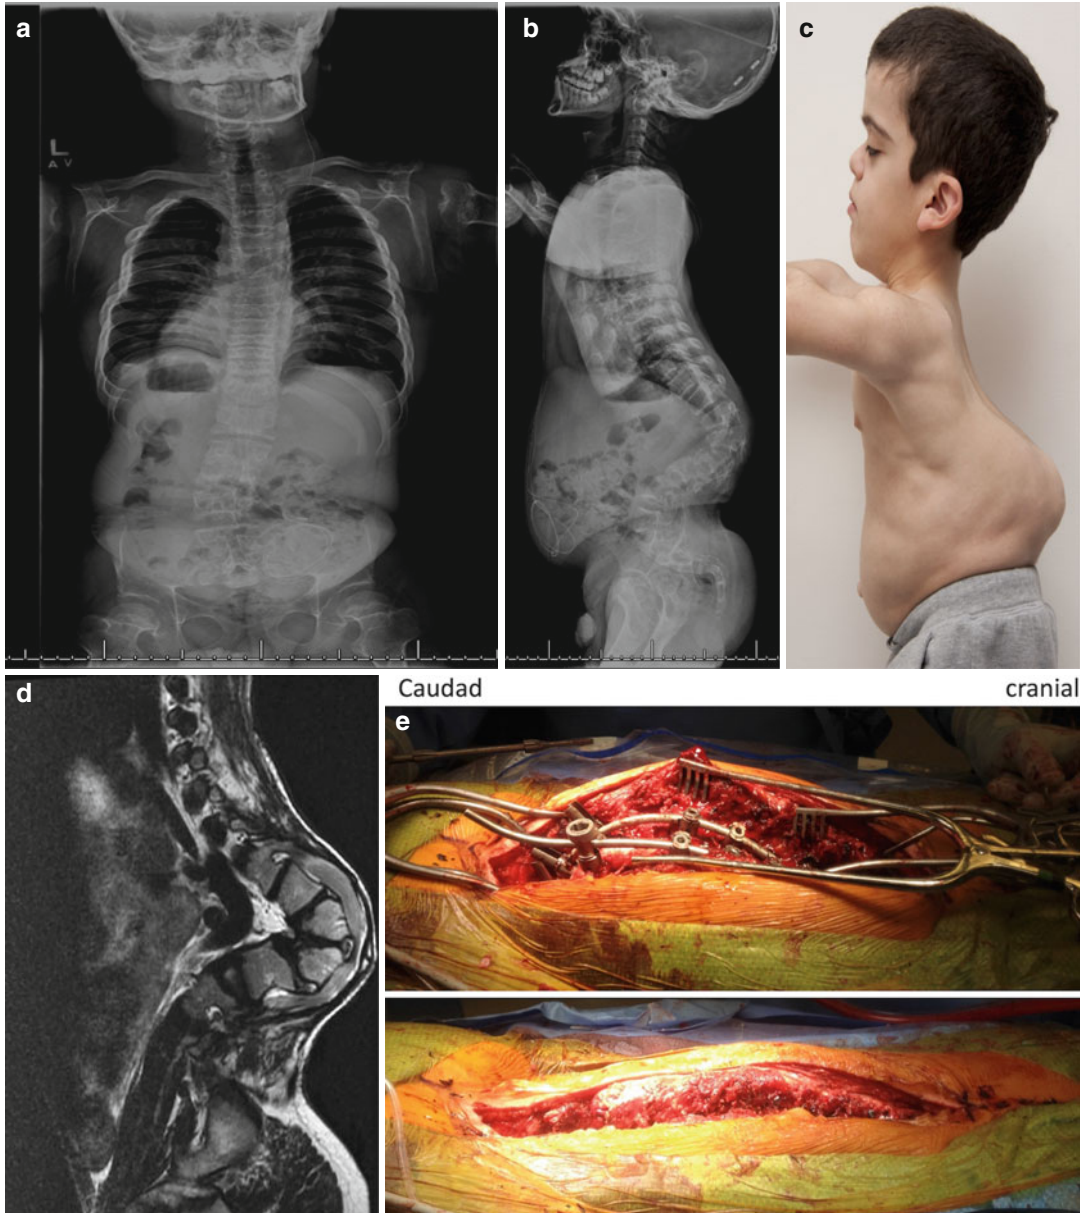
Significant thoracolumbar kyphosis after previous attempts at management in a 15-year-old with achondroplasia and symptoms of neurogenic claudication as shown in AP (a) and lateral (b) X-rays. Clinical photo of thoracolumbar kyphosis (c). Other features include bifrontoparietal bossing and mid-face hypoplasia. He underwent
